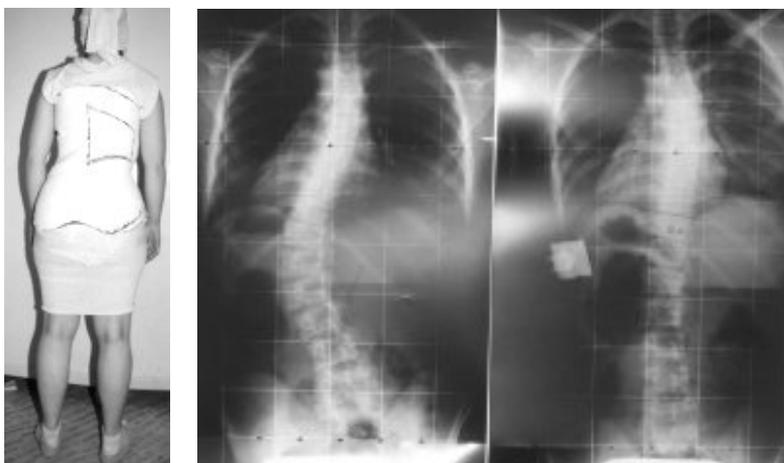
Risser plaster brace for a thoraco-lumbar scoliosis, with radiographs showing the correction obtained (the radio-opaque push can be clearly seen).
